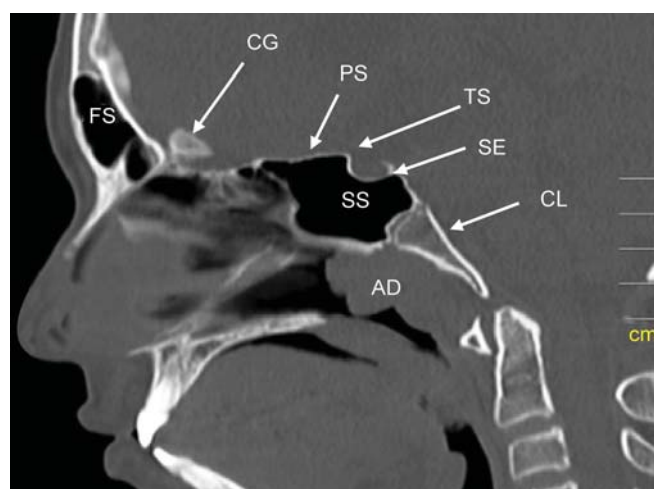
Sagittal CT bone window: FS: Frontal sinus; CG: Crista galli; PS: Planum sphenoidale; TS: Tuberculum sellae; SE: Sella; Cl: Clivus; SS: Sphenoid sinus; AD: Adenoids
